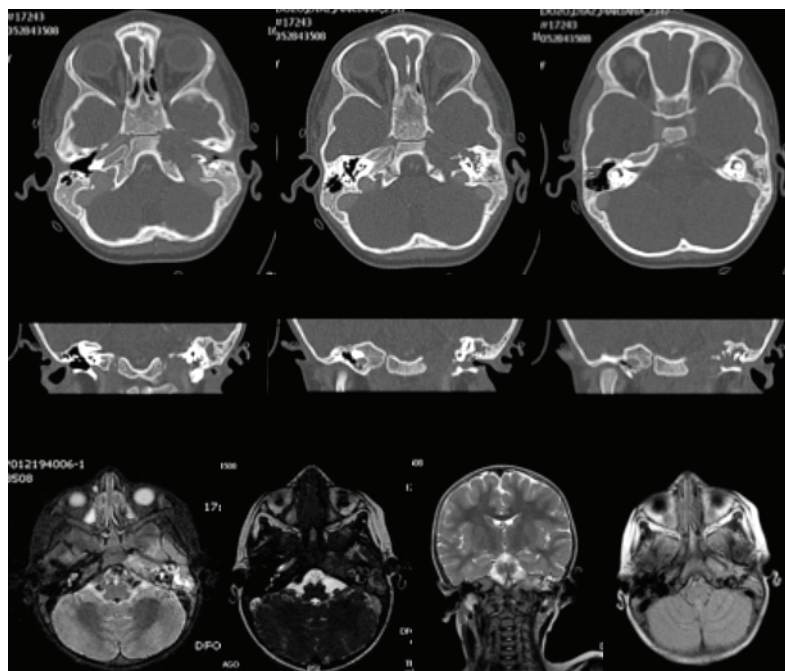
CT scan and MRI where it is possible to see an osteolytic lesion compromising the petrous part of the temporal bone with erosion towards the jugular foramen and structures of the inner ear.
